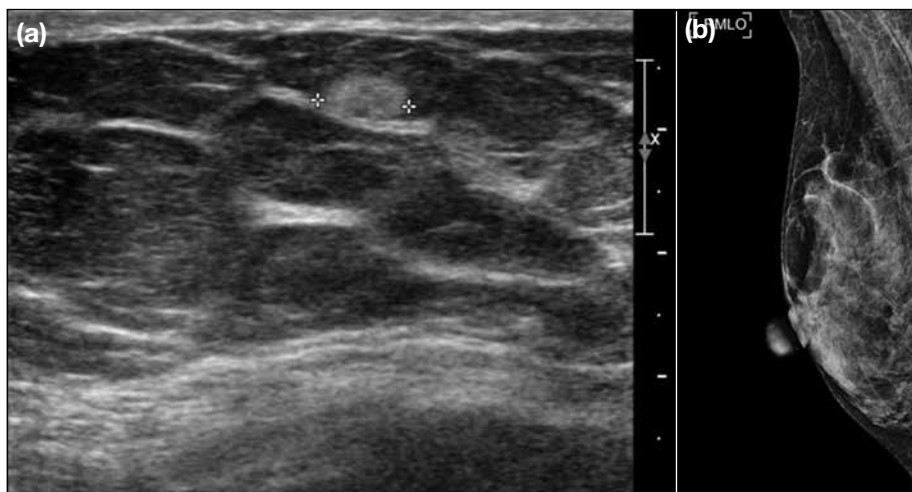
(a) Ultrasonogram of a 51-year-old woman who presented with a palpable lump at the lower outer quadrant of the left breast showing a subcutaneous oval parallel circumscribed hyperechoic lesion with no posterior features, calcifications or vascularity. It was pathologically confirmed to be a lipoma. (b) Right medio-lateral-oblique mammogram of a 63-year-old woman who presented with a palpable lump, showed a radiolucent mass with no calcification at the subcutaneous layer of the upper part of the right breast, indenting on the glandular tissue. Mammographic findings were typical of a lipoma.
